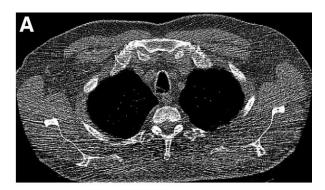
PET/CT protocols with and without IV contrast. Shown are 3 commonly used protocols in PET/CT imaging. (A) The first protocol uss the CT for attenuation correction and localization purposes; however, the CT is inferior quality to a CT scan performed at full dose with oral and IV contrast, as performed for the second protocol (B). The last protocol (C) uses the first low-dose CT for attenuation correction to avoid artifacts caused by contrast and uses the second full-dose contrast-enhanced CT for diagnostic purposes.
